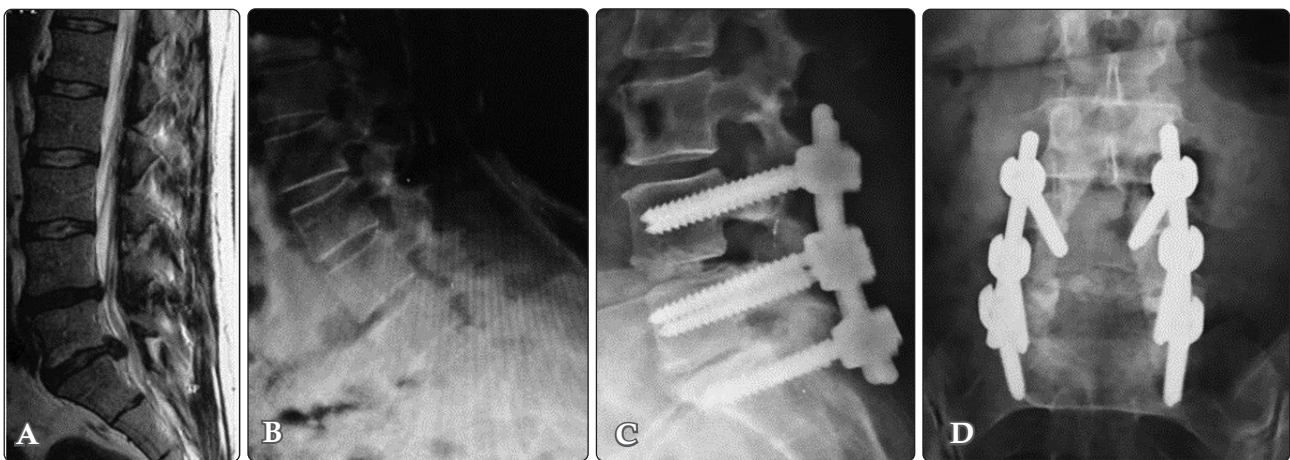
Images of a 52-year-old female patient, non-smoker, low vitamin D, ODI= 48, VAS= 8. (A) Sagittal T2 MRI showing with degenerative disc changes at L4-L5 and L5-S1 levels, with a disc herniation at L5-S1 level. (B) Dynamic study showing no instability. Postoperative plain radiographs 6 months postoperatively, (C) lateral view, and (D) anteroposterior view show bone graft seen in the L4-L5 space; however, lucency could be seen above and below the graft (Bridwell's grade 3); in the L5-S1 level, the bone graft cannot be readily seen, indicating bone graft resorption and complete failure of fusion (Bridwell's grade 4).
